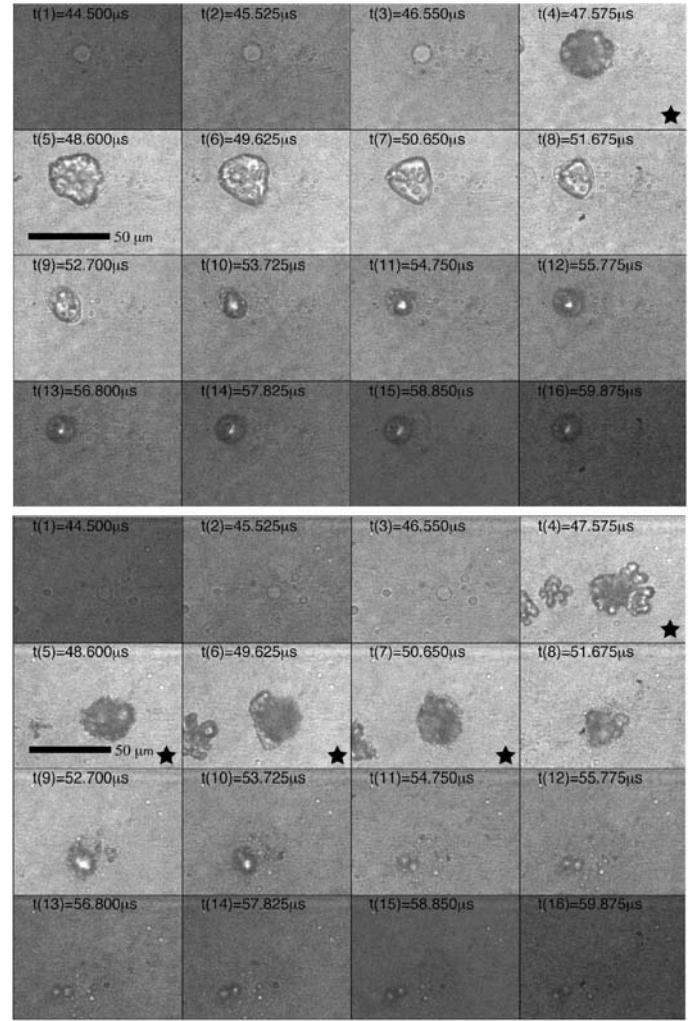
Sixteen image sets showing vaporization using approximately two-cycle tone bursts (top) and thirteen-cycle tone bursts (bottom). The presence of ultrasound during a frame is denoted by a star. The timing of the frames is seen in the upper left of each frame. The key difference between the two conditions is that not all of the DDFP phase-transitions when only a two-cycle tone burst was used. Note that the differences in intensities between frames is a result of the duration of the flashlamp.
